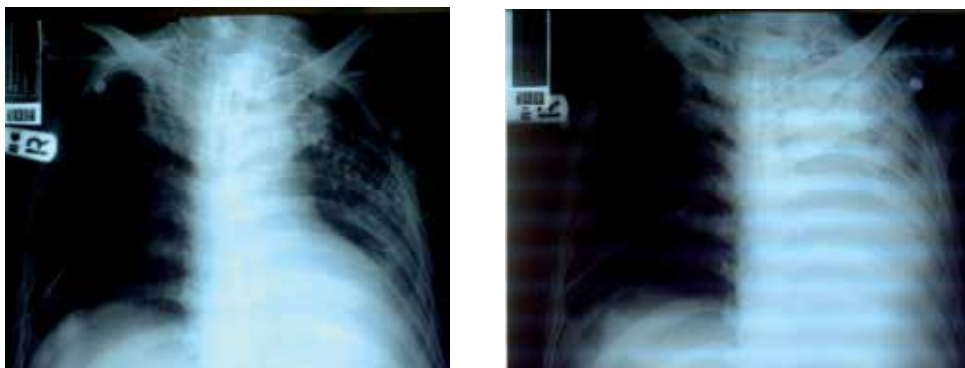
Chest radiograph showing atelectasis of the left lung, and pneumothorax at the right lung with ICD before treatment (right) and after 3 days of treatment showing improvement of aeration in the left lung with atelectasis of the left lower lobe (left).
